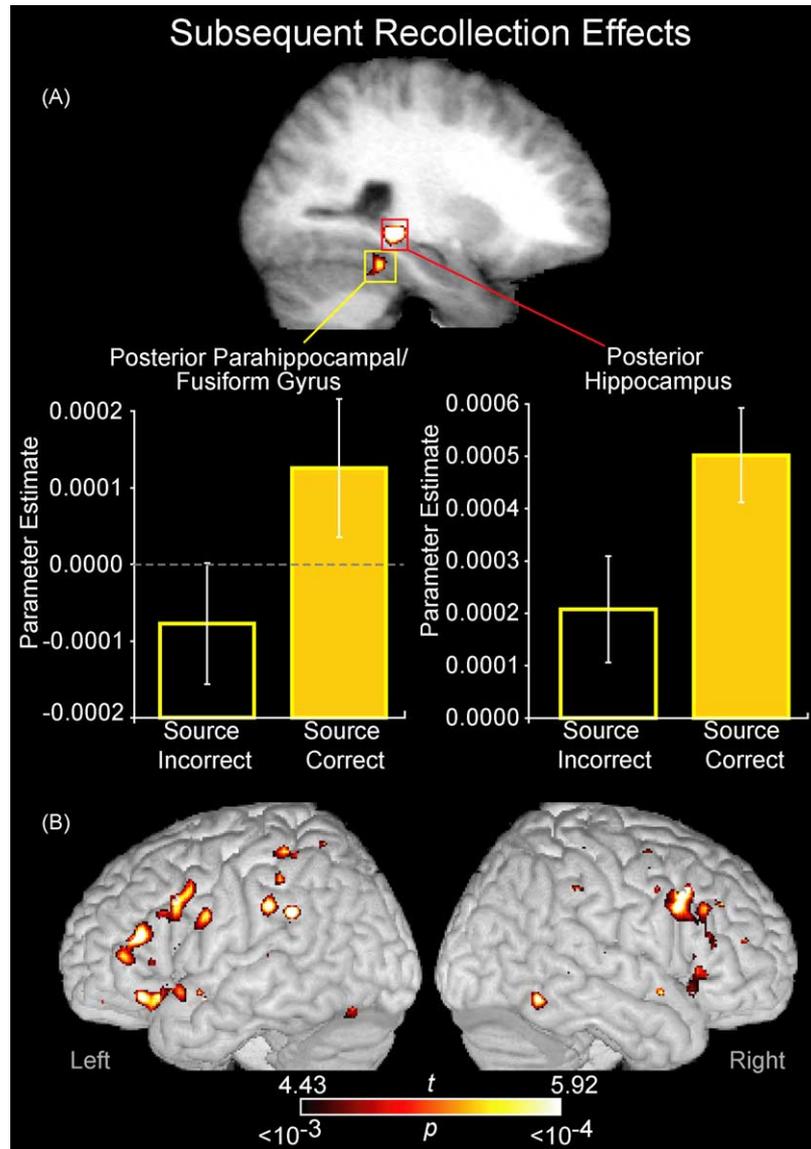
Subsequent recollection effects as indexed by source memory accuracy. (A) Two MTL regions that exhibited subsequent recollection effects—the posterior hippocampus (shown within the red square) and the posterior parahippocampal cortex (shown within the yellow square)—are overlaid on an averaged T1-weighted image. Plots of the parameter estimates (indexing response amplitude) for recognized items eliciting correct (filled bars) vs. incorrect source judgments (open bars) are shown for each of these regions. (B) Other regions of cortical activation are rendered on a template brain.
